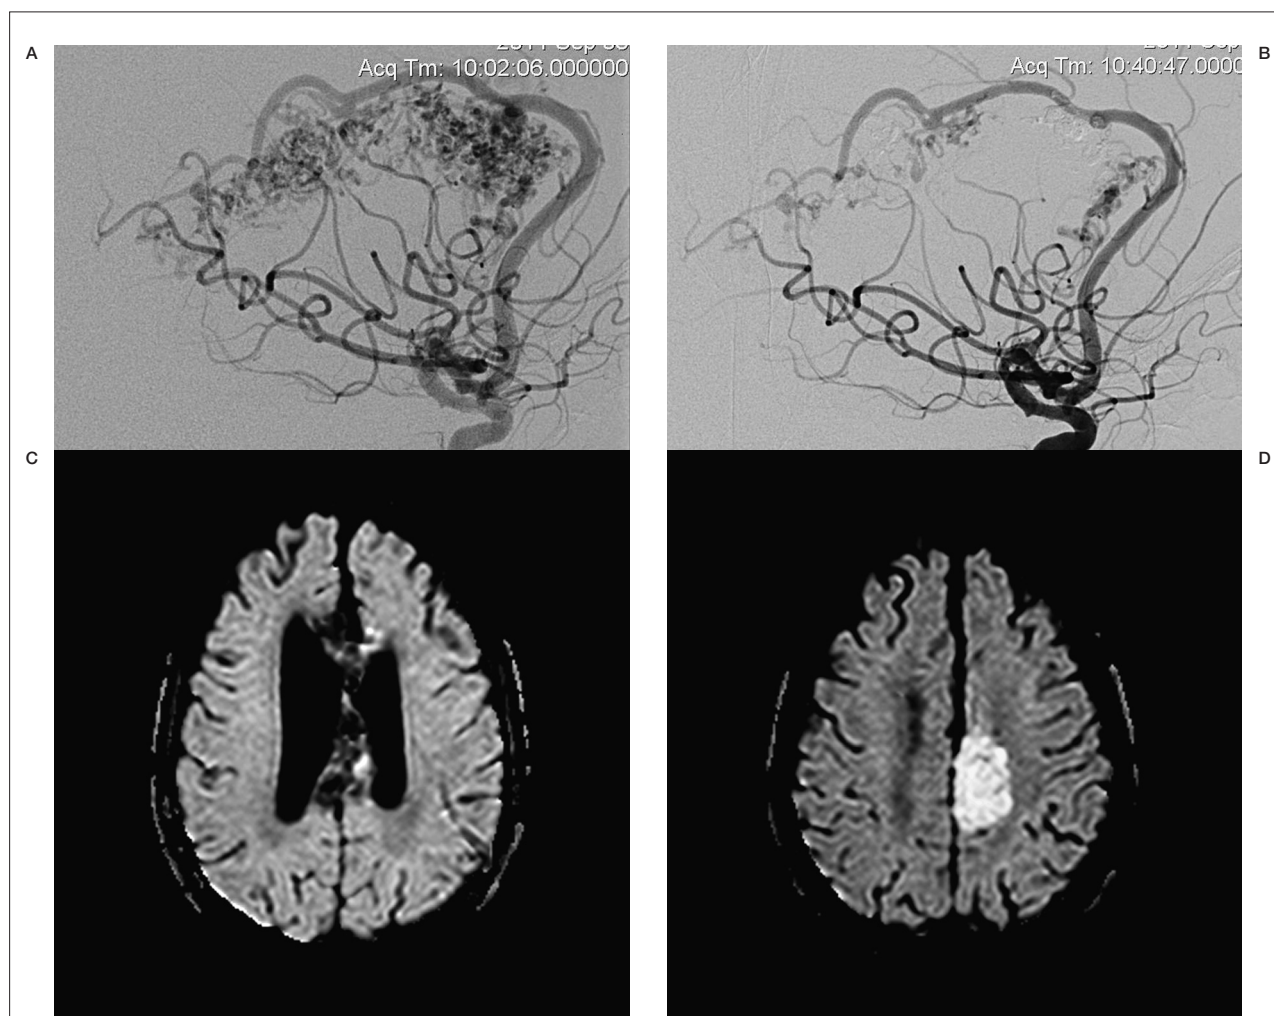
Intra- and extranidal lesions in DW-MRI after a second embolization of a pericallosal AVM in a 28-year-old male. According to pre- and post-interventional angiograms (A, B), the nidus occlusion rate was estimated to 80%. DW-MRI (C, D) showed small intra- and perinidal hyperintensities probably corresponding to occluded vessels and a larger extranidal lesion representing an infarction.
